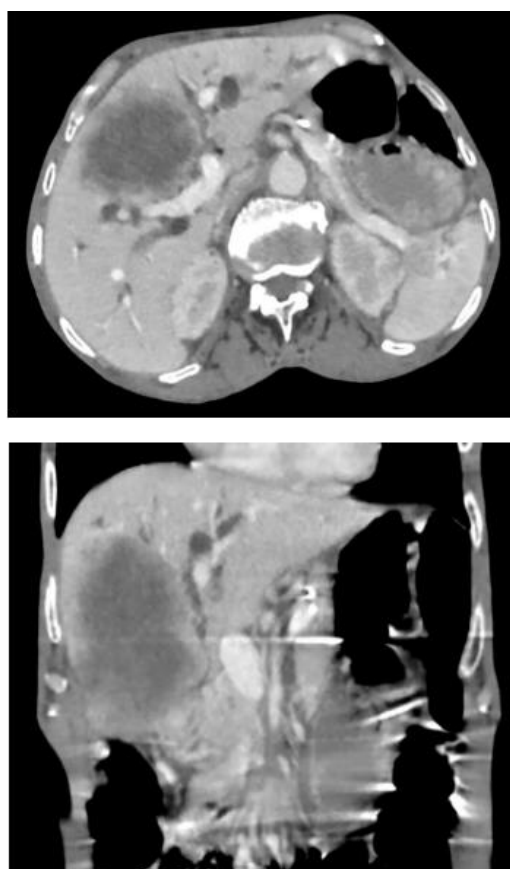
Contrast-enhanced CT demonstrating a large heterogeneously enhancing soft-tissue mass arising from the fundus and body of the gallbladder, with direct infiltration of adjacent hepatic segments IVa, IVb, V, and VIII. Moderate dilatation of the intrahepatic biliary radicles is also noted.
